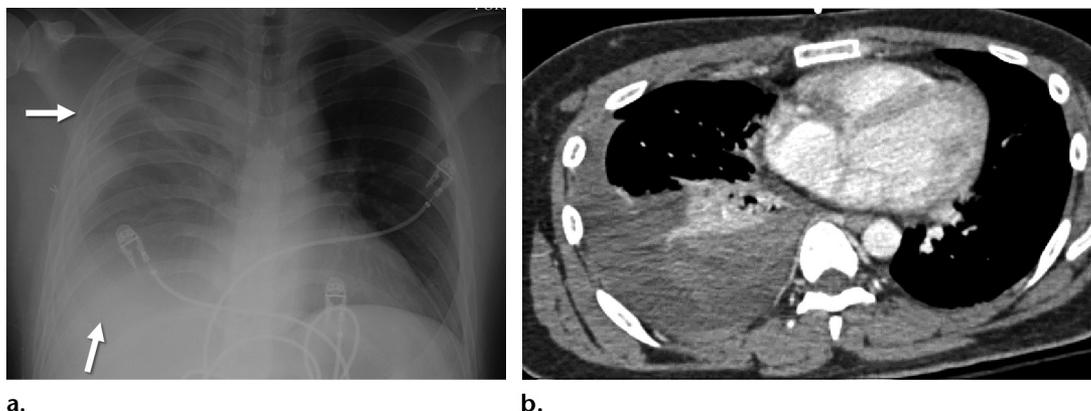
Hemothorax in a patient with neck swelling and dyspnea 8 days after right paraclavicular thoracic outlet decompression surgery. (a) Chest radiograph shows a right pleural fluid collection with lateral and subpulmonic components (arrows). This new and relatively rapidly accumulating pleural fluid collection was worrisome for a hemothorax. (b) CT image shows high-attenuation material in the right pleural space, consistent with blood products. The patient underwent operative evacuation of the hemothorax.
